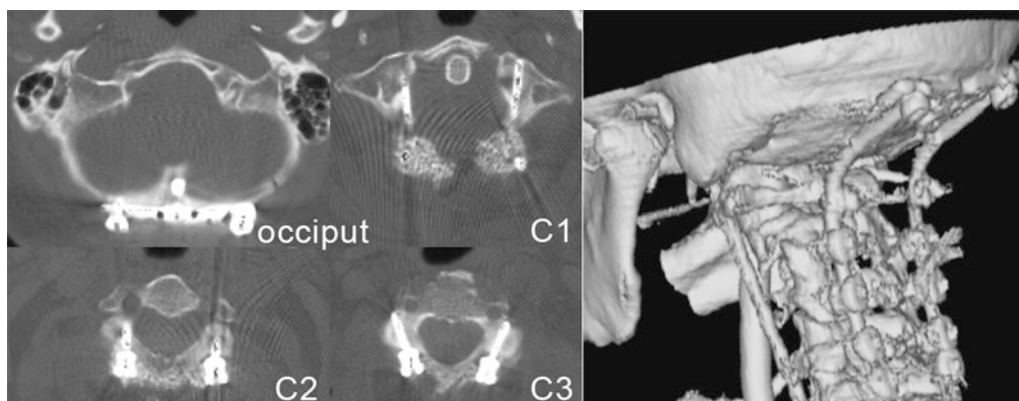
Intraoperative CT Scan of a patient having received an occipital-cervical fixation down to C3. Note the different orientation of the screws within the occiput. The reconstruction of the position of the implants is on the right
